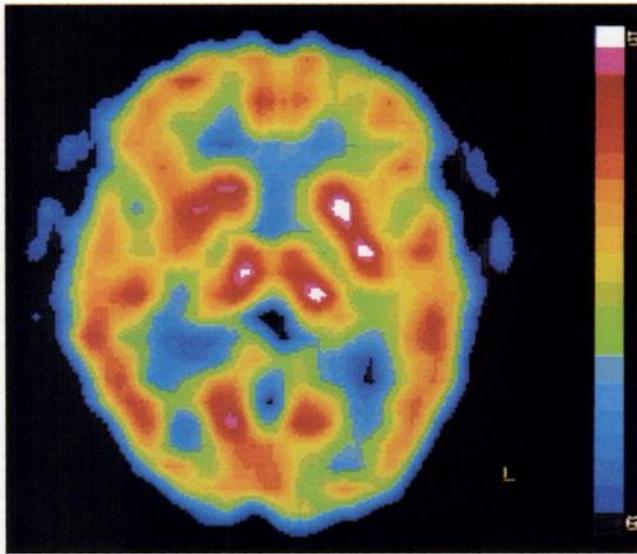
Representative SPECT slice at basal ganglia level from patient with SHE and poor neuropsychologic performance shows high activity in basal ganglia and thalamus and mild left prefrontal hypoperfusion.
